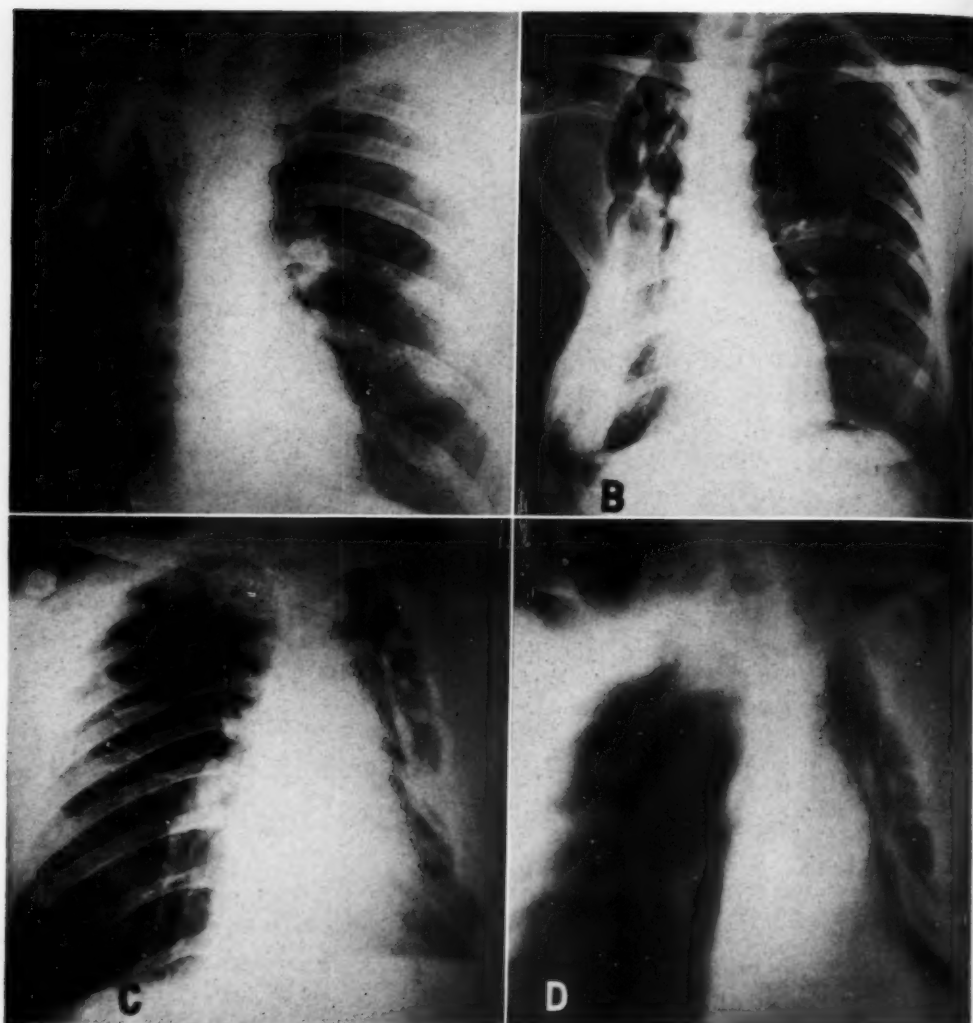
A. Roentgenogram showing "localized lateral convexity" and underlying cavity with fluid level; sputum positive. B. Roentgenogram showing lateral bulge or herniation resulting from complete loss of periosteum; sputum positive. C. Roentgenogram following revision operation showing a persisting "lateral convexity." Minimal rib regeneration resulting from loss of periosteum in repeated operations; sputum positive. D. Tomographic roentgenogram of same patient showing annular shadow underlying lateral convexity.
